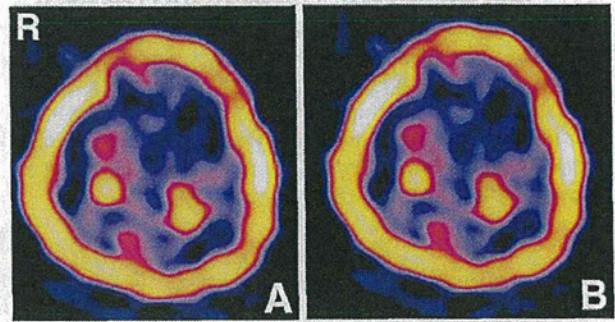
Thallium-201 chloride single-photon emission computed tomography scans showing marked uptake (tumor to non-tumorous brain ratio) on both early (A: right 11.81, left 13.68) and delayed images (B: right 3.08, left 3.09), and negative retention index (right -73.91, left -77.4), suggesting good washout.
